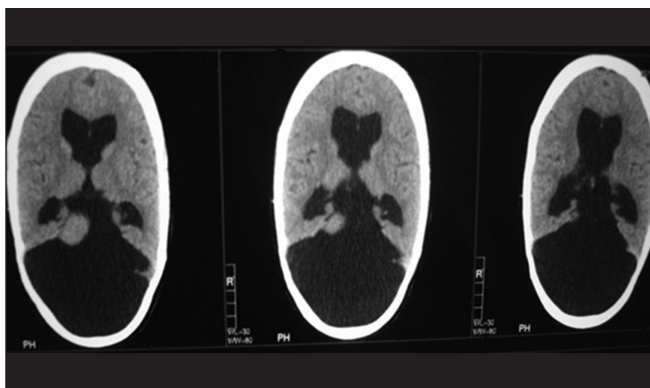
Computed tomography brain shows dandy walker malformation with vermian hypoplasia. Partial agenesis of corpus callosum and colpocephaly with obstructive hydrocephalus
